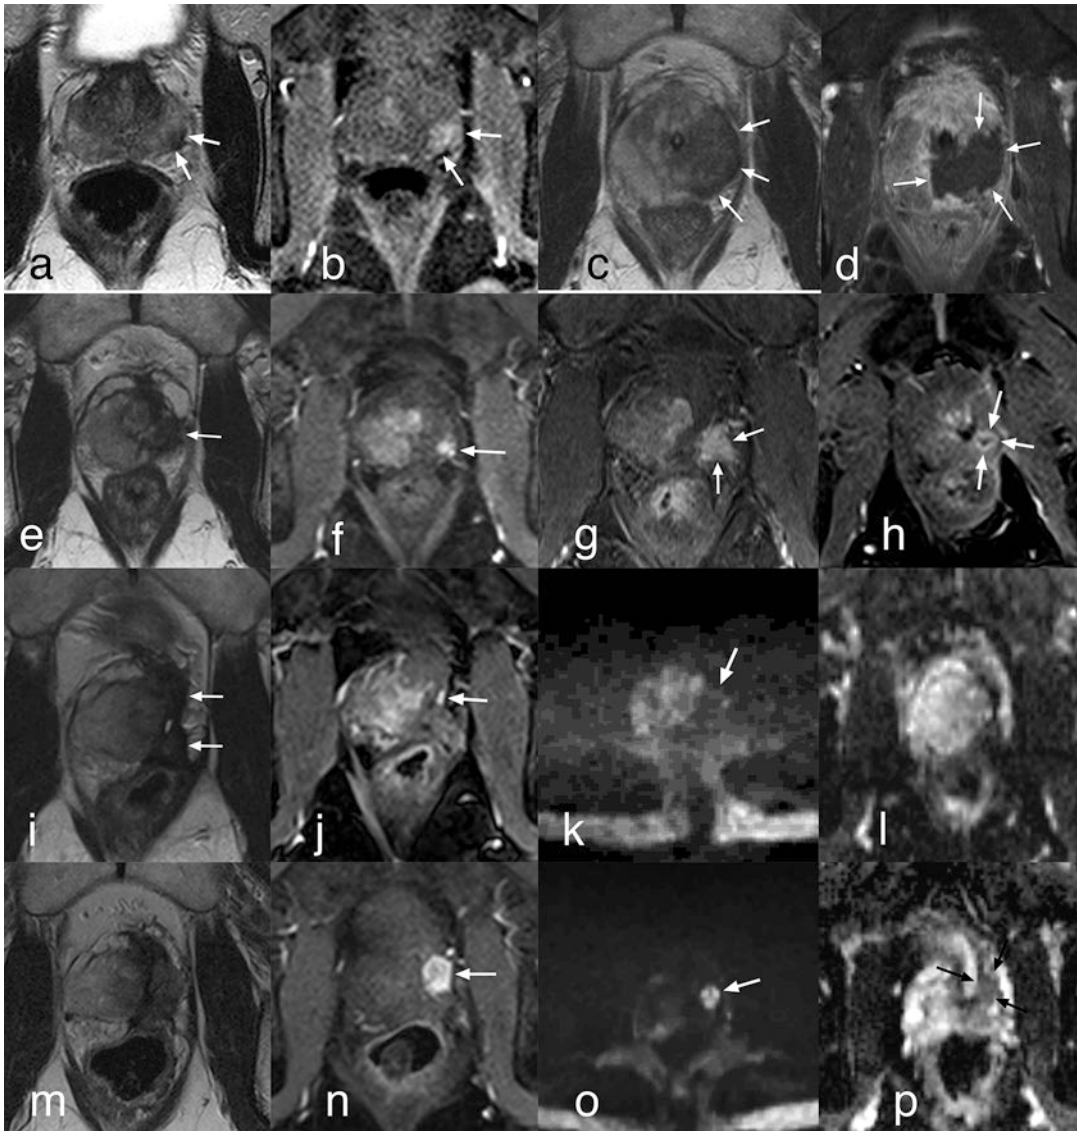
A series of MRI scans in a 67-year-old man before and after focal ablation to a lesion in the left peripheral zone. (a, b) T2 and early dynamically enhanced sequences with arrows showing the original tumor (Gleason 3+4 on template transperineal biopsy) in the left posterolateral peripheral zone (PSA 5.7). (c, d) T2 and late enhanced sequences 1 week after treatment. The left hemiablation is easy to appreciate (arrows) on the enhanced sequences, but the margins of the ablation are very difficult to define on T2. A little patchy enhancement remains in against the posterior capsule. (e, f) T2 and early dynamically enhanced sequences 6 months after focal HIFU. The PSA has fallen to 0.7. The T2 sequence shows atrophy and low signal in the treated zone, but does not reveal a focal tumor. The dynamically enhanced image shows a 5 mm diameter focus of residual tumor (arrow) on the left, which was targeted at transrectal biopsy, but missed (atrophy only on biopsy). Note the diffuse enhancement on the opposite (right) side:
